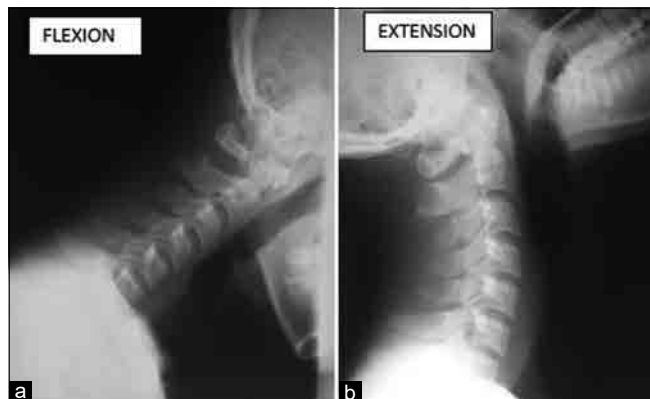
Lateral cervical spine (a) flexion and (b) extension X-ray taking on the 18th day posttrauma.
